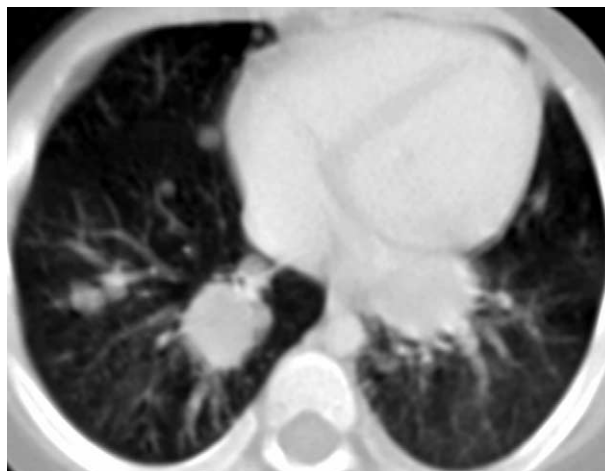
Axial CT section through the thorax (lung window settings) demonstrating multiple soft-tissue nodules throughout the right lung.
